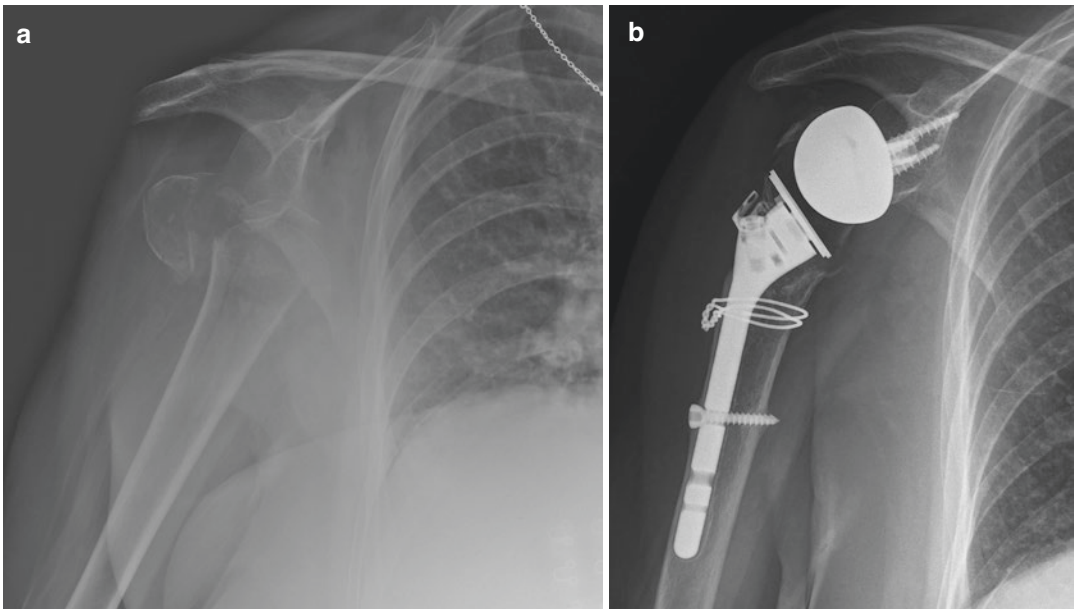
Preoperative X-ray image of an 83-year-old female who sustained a fracture–dislocation of the proximal humerus after a fall at home (a). RSA was performed with good results in terms of pain and especially restoring
